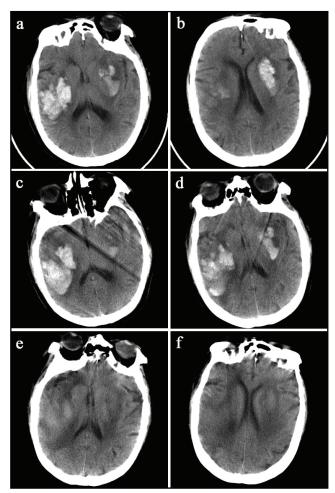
Computed tomography scans at 34 hours (a, b) and 48 hours (c, d) after the first hemorrhage, demonstrating a right temporal-occipital hemorrhage (multiple hemorrhages), without evidence of a midline shift. Follow-up computed tomography scan 1 month (e, f) after the first hemorrhage, showing resolution of the hemorrhages.
